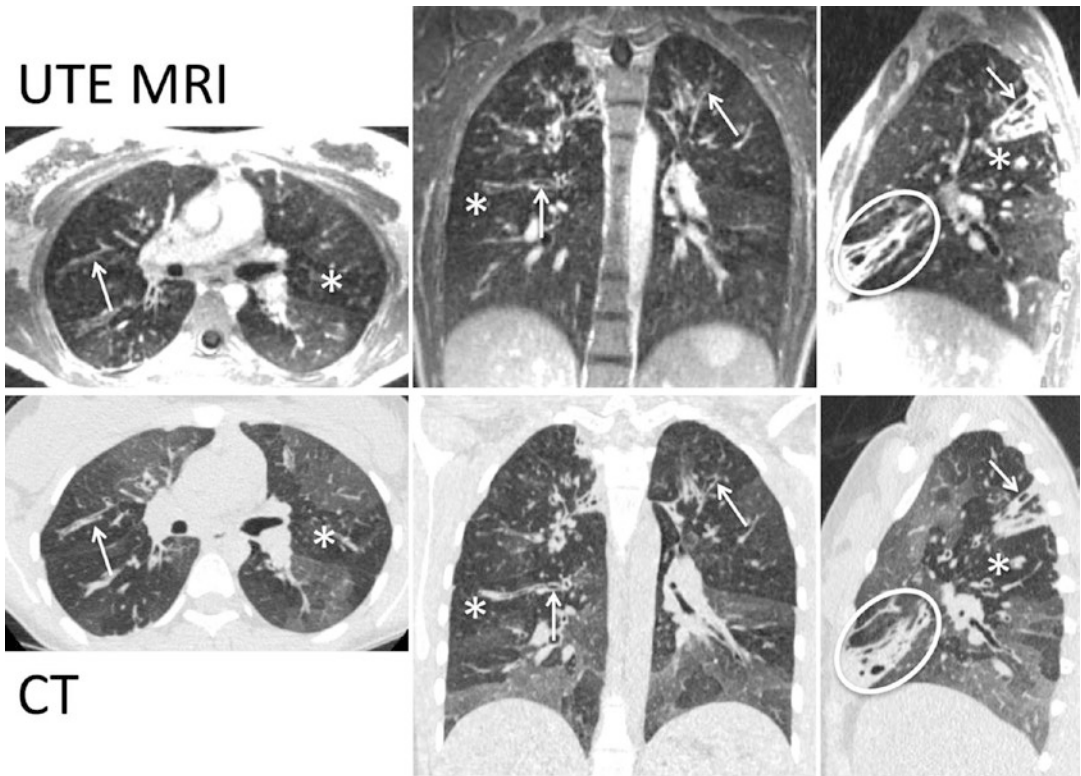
Ultrashort echo time ($TE < 0.1$ ms) MRI of the lungs in cystic fibrosis clearly shows a mosaic pattern (*), likely to be air trapping based upon comparison with expiratory CT images, much better than conventional echo time methods. Although the UTE MRI images have slightly lower in-plane spatial resolution than CT, the depiction of bronchiectasis and bronchial wall thickening
